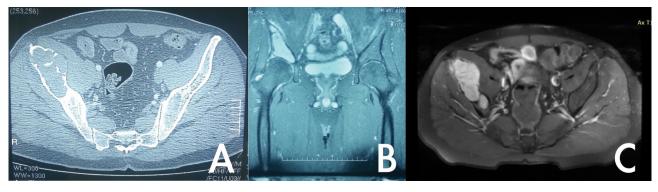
A. Preoperative axial computer tomography of a 45-year-old patient with right periacetabular osteogenic sarcoma. B, C. Intramedullary osteogenic sarcoma in the right periacetabular region in coronal and axial T2 contrast-enhanced magnetic resonance images of the same patient.
